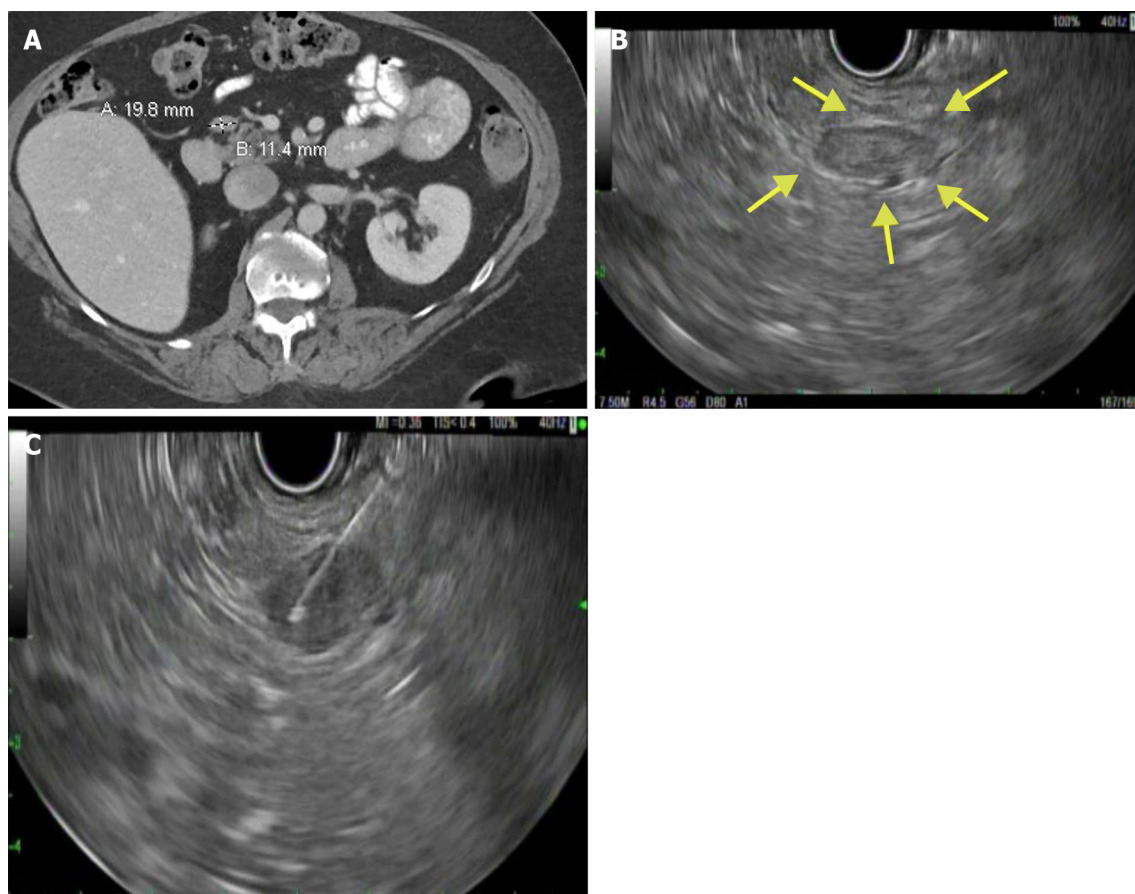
Computed tomography and endoscopy examinations. A: Computed tomography of abdomen pelvis showing a peripancreatic lymph node adjacent to the pancreatic head; B: Endoscopic ultrasonography showing a hypoechoic lesion near the pancreatic head; C: Endoscopic ultrasound-guided fine needle aspiration of the peripancreatic lesion.
